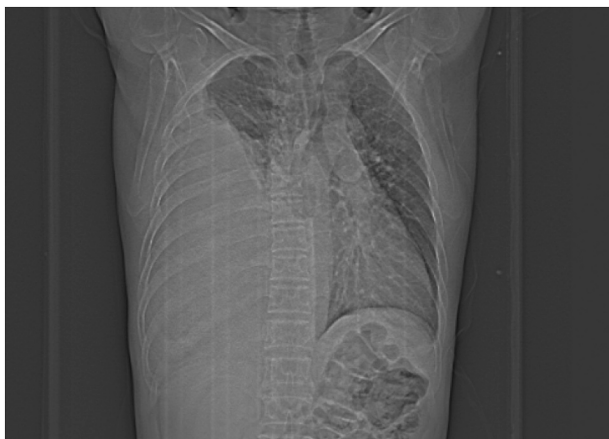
Plain film showing huge opacity of the right hemi-chest.
